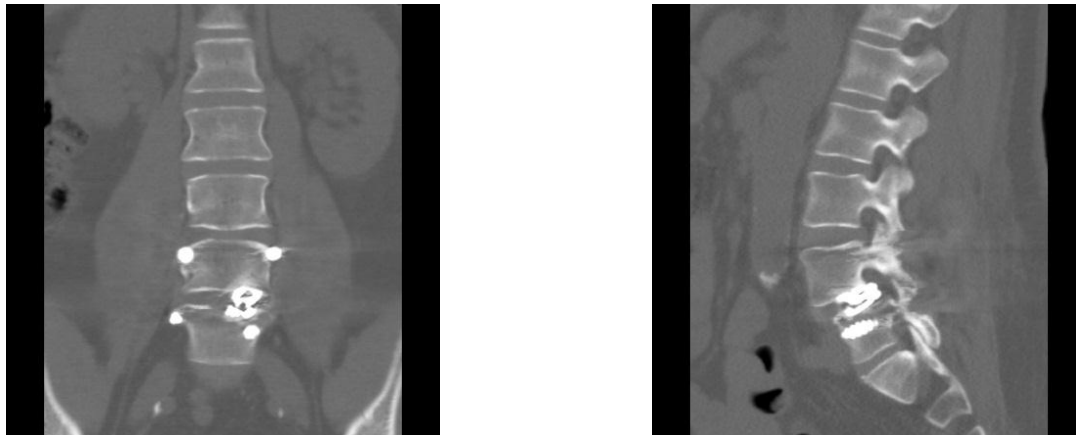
CT showing psuedoarthrosis of the L4-L5 level with displacement of the interbody cage.
